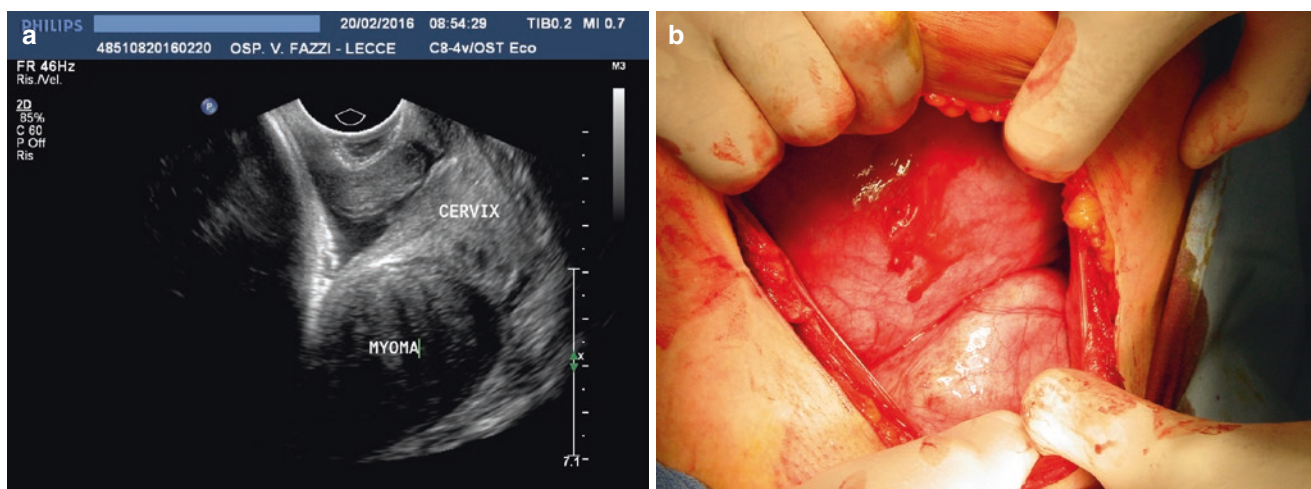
(a) Transvaginal ultrasonographic scan showing a posterior cervical fibroid at 36 weeks of pregnancy. (b) Intraoperative image of a large cervical fibroid during cesarean section
